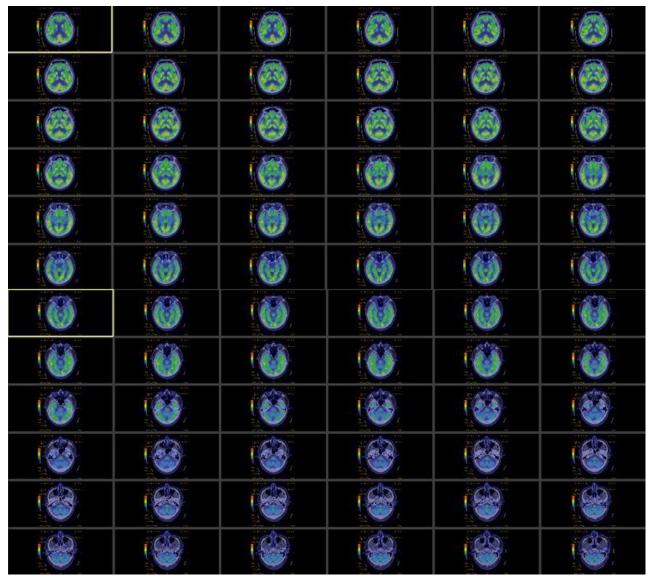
PET-CT Brain scan shows decreased uptake in both primary motor cortices, thalamus, midbrain, and cerebellum.
